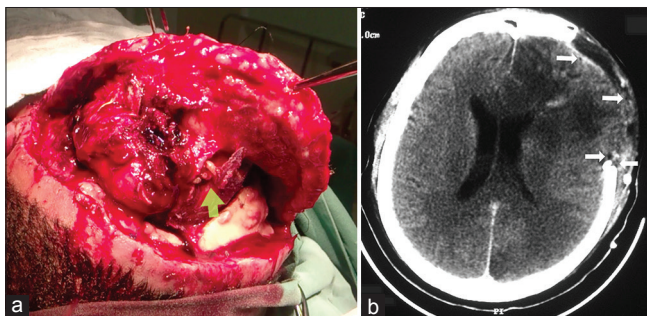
(a) Surgical reapproach showing the presence of larvae on the surgical bed (arrow). (b) Computed tomography showing small, rounded, and regular hypodense images at the surgical site (arrows)
